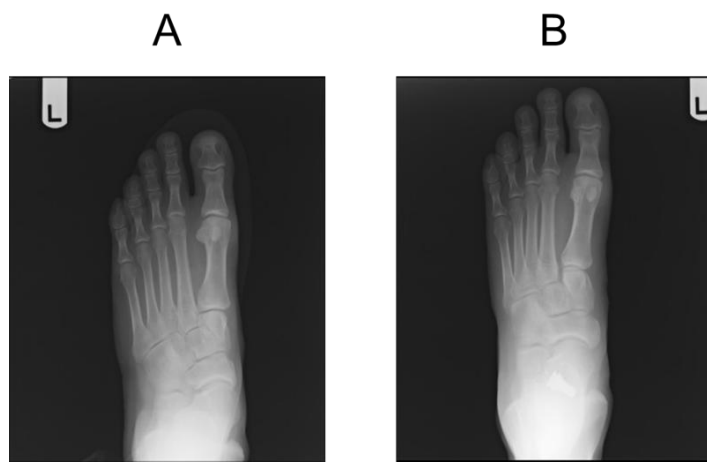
Weight-bearing dorsoplantar foot radiographs of a patient exhibiting talotarsal joint dislocation (TTJD) with a transverse plane deformity (A) before correction and (B) after insertion of an extraosseous talotarsal stabilization Type II implant. Stabilization and normalization of the transverse deformity is shown.
